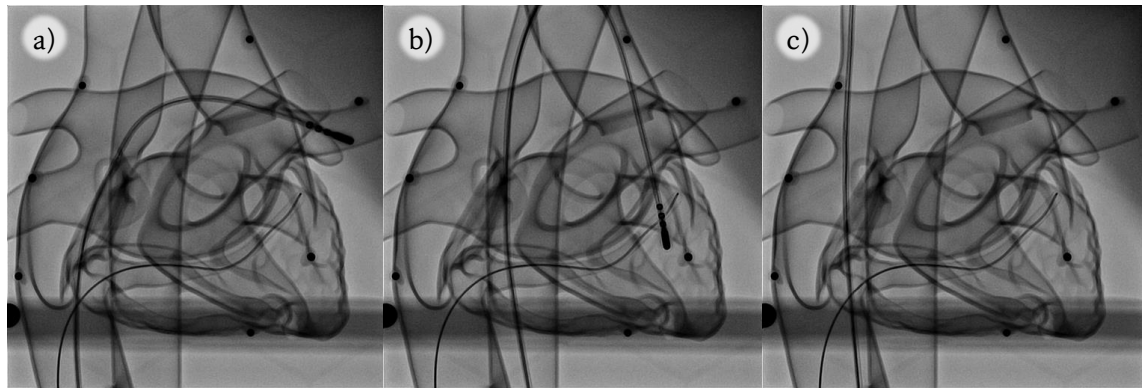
a) In this posterior-anterior X-ray view, the CS of the glass heart is catheterised with a guidewire via the IVC and a second catheter is inserted into the LUPV via the IVC, b) the LV via the DAo and c) the SVC via the IVC.
